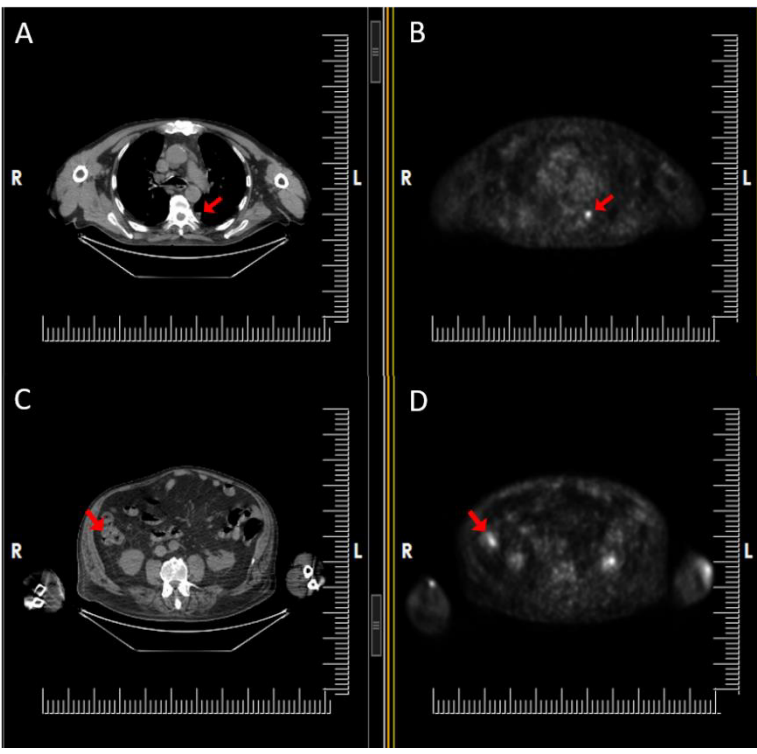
Oncologic Positron Emission-Computed Tomography (PET-CT) images of squamous cell lung carcinoma (A, B) in the superior segment of the left lung lower lobe and adenocarcinoma (C, D) in the ascending colon.
